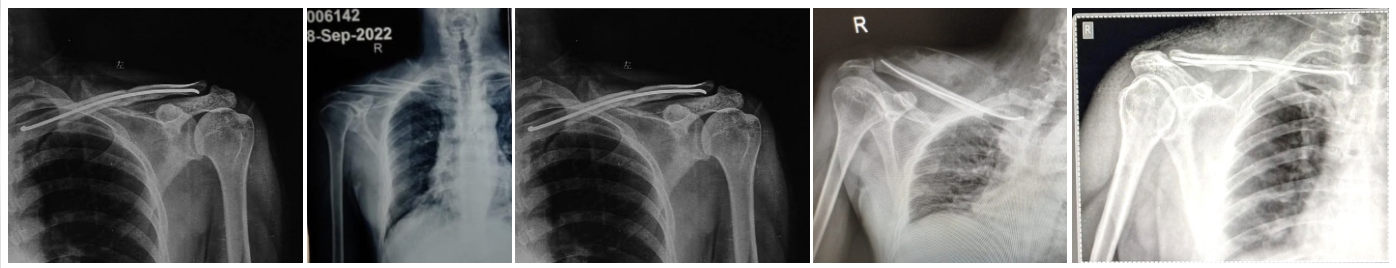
The post operative X-ray after 4 weeks of one of our patient 46 year Male with mid shaft fracture of clavicle
